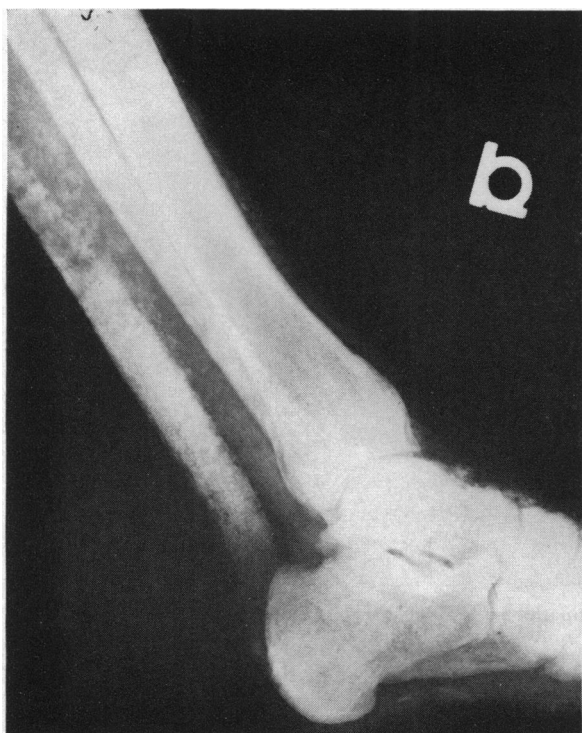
X-ray film showing calcification in the soft tissues of the foot.
